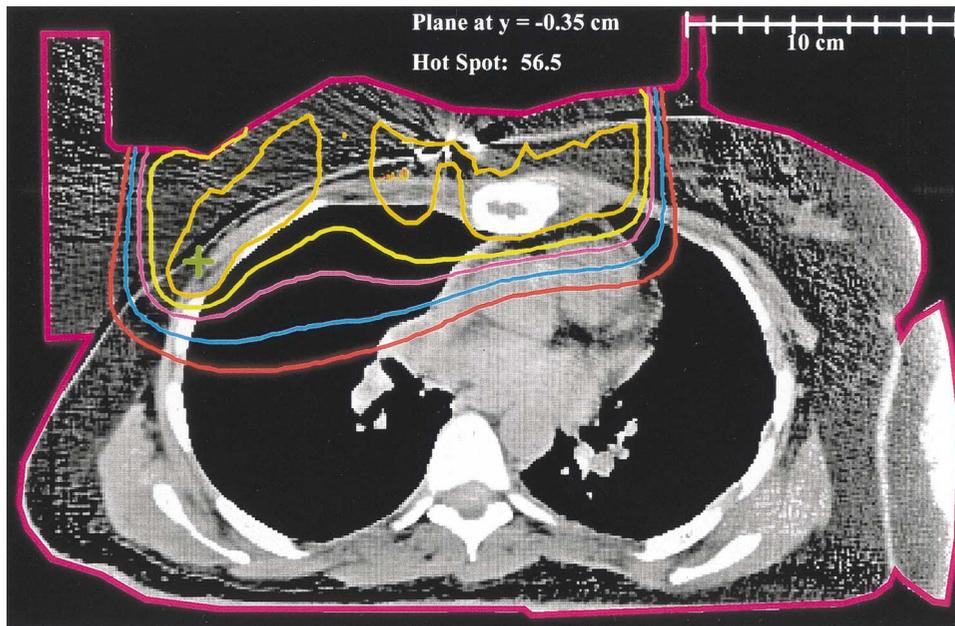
Isodose distribution (Gy) using the custom 3D electron bolus technique for the same patient as in Figure 7. A dose of 50 Gy was prescribed to 100% of the given dose using 16-MeV electrons; the custom electron bolus was placed on the patient's skin and is visible in the CT image. To verify correct fabrication and positioning of the electron bolus, this dose distribution was compared to the dose distribution for the treatment plan shown in Figure 7.
